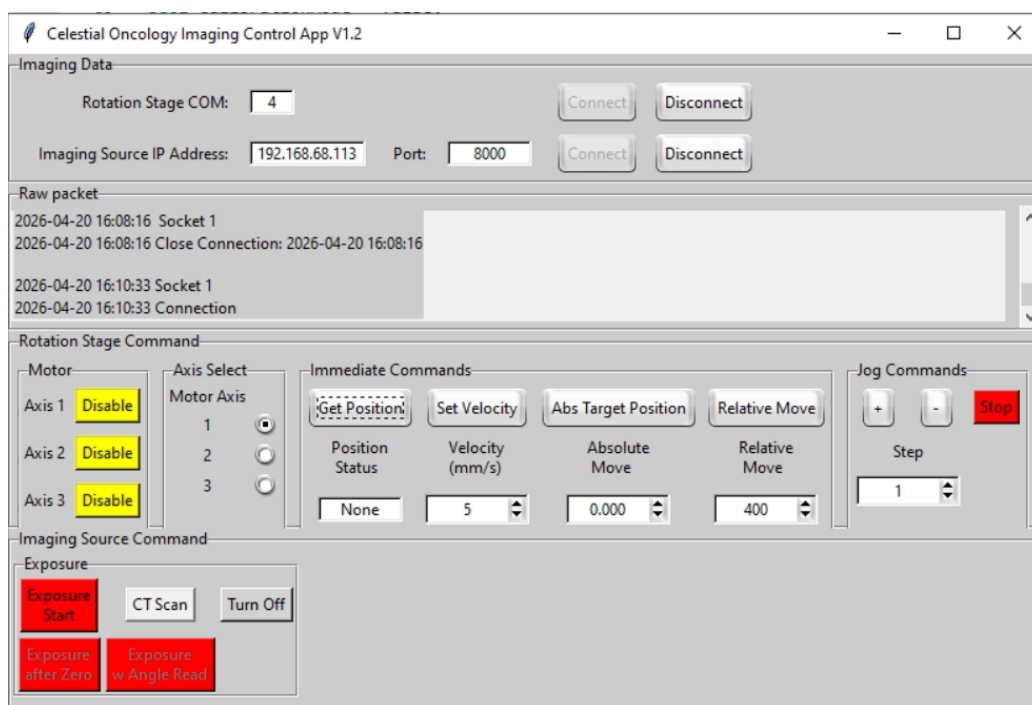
User interfaces for the X-ray source configuration, detector, and stage-exposure control software, respectively from top to bottom.
